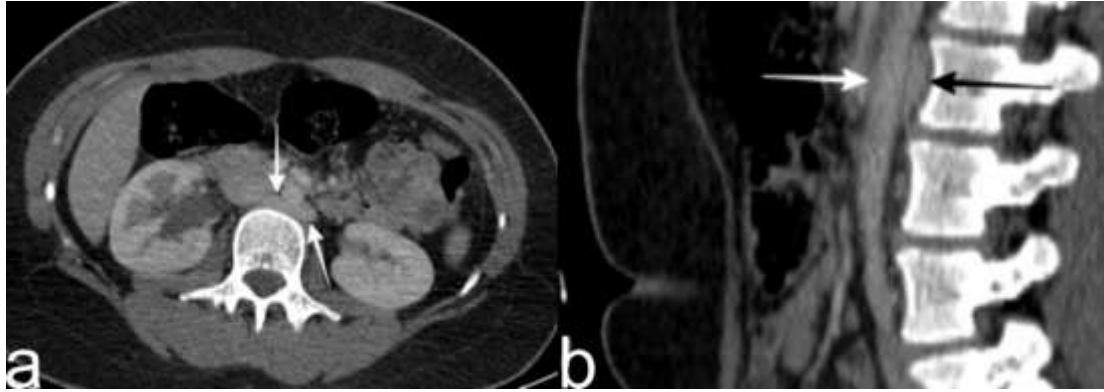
A 37-year-old female patient. a. Axial multidetector computed tomography (MDCT) images demonstrate retroaortic left renal vein (RLRV) (white arrows). b. Sagittal multiplanar reconstruction (MPR) images show RLRV (black arrow). Aorta is seen in front of the RLRV (white arrow).
